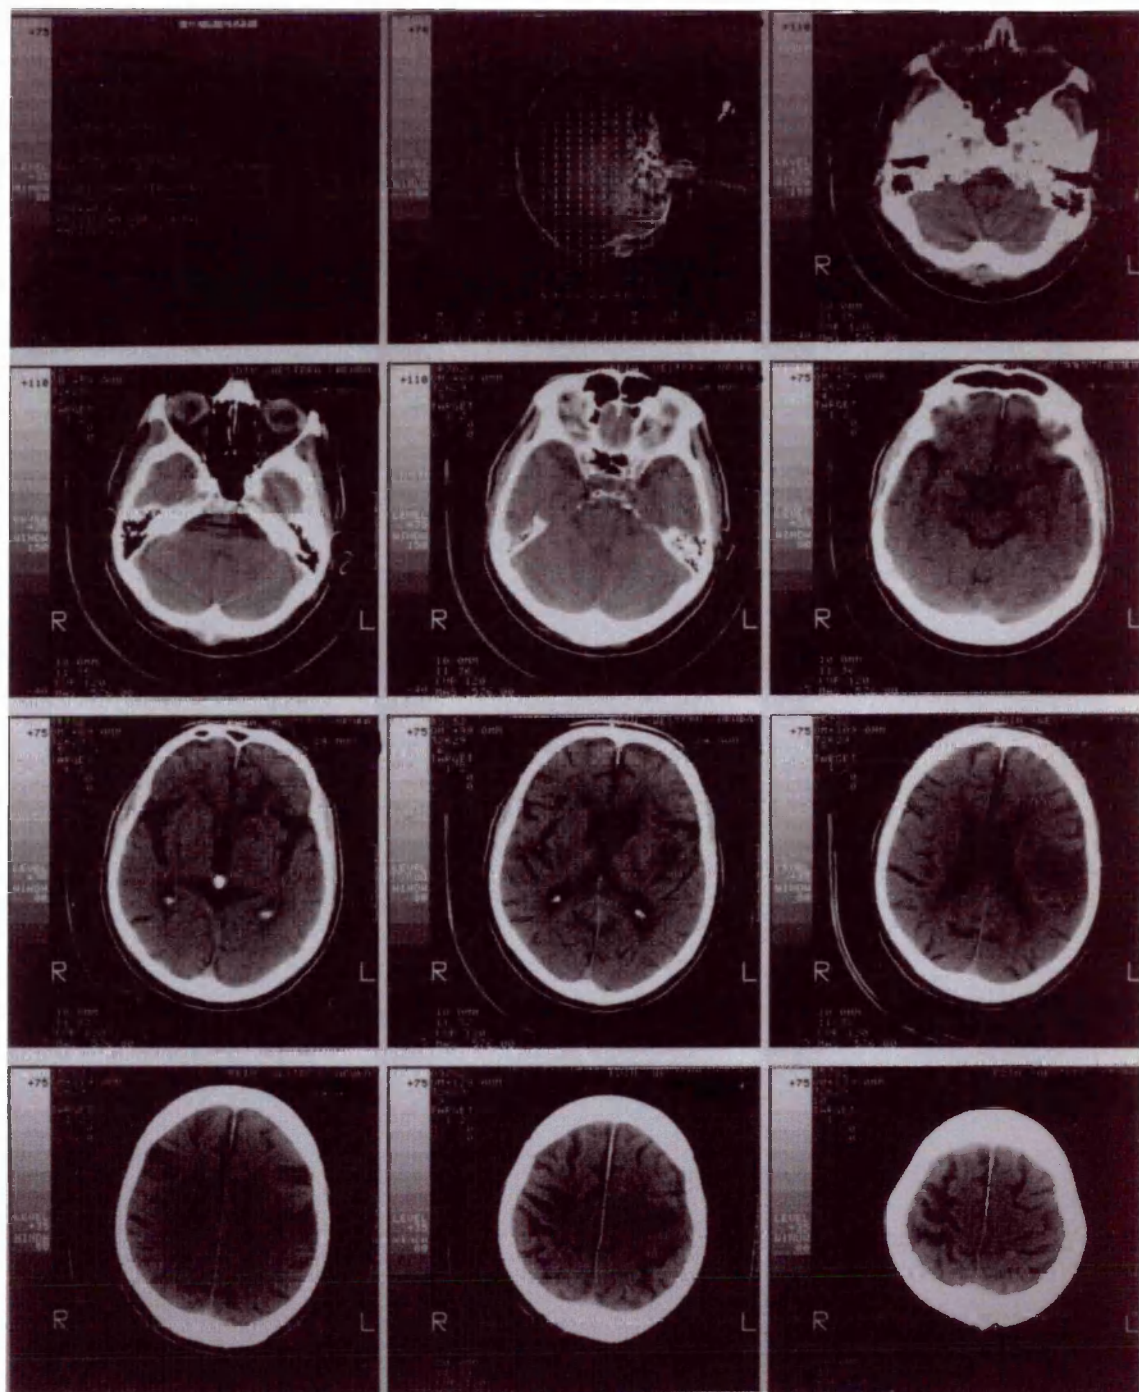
CT scan for FC.
